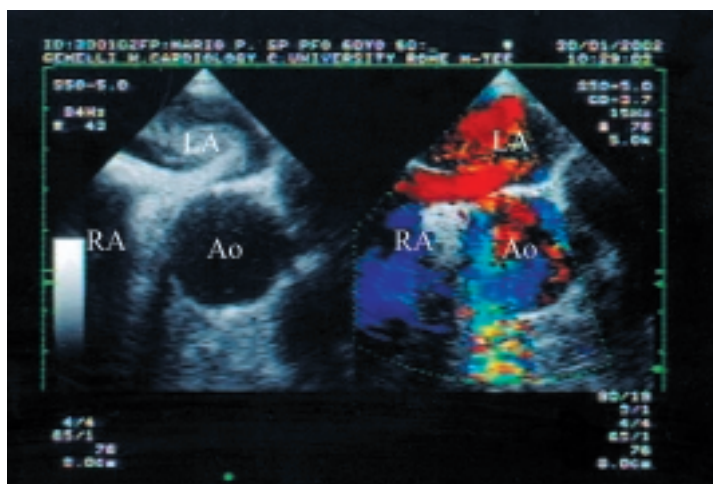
Transesophageal echocardiography after contrast injection (left) and with color Doppler imaging (right), showing a patent foramen ovale with a right-to-left shunt. Ao = aorta; LA = left atrium; RA = right atrium.
